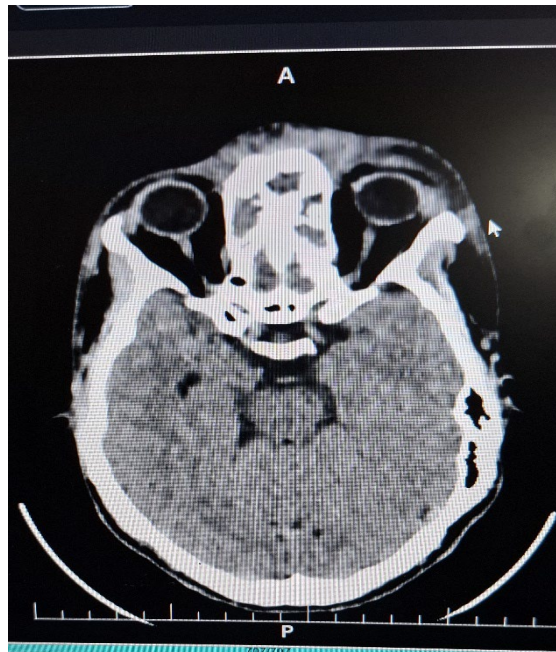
Axial CT scan showing preseptal cellulitis.
